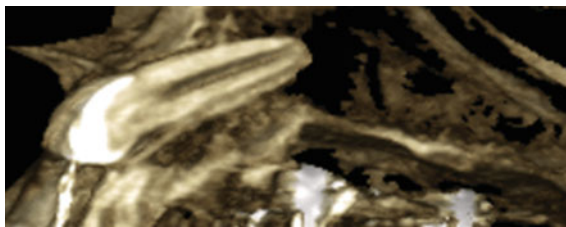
CBCT 3D reconstructions of impacted 23 in vestibular position
